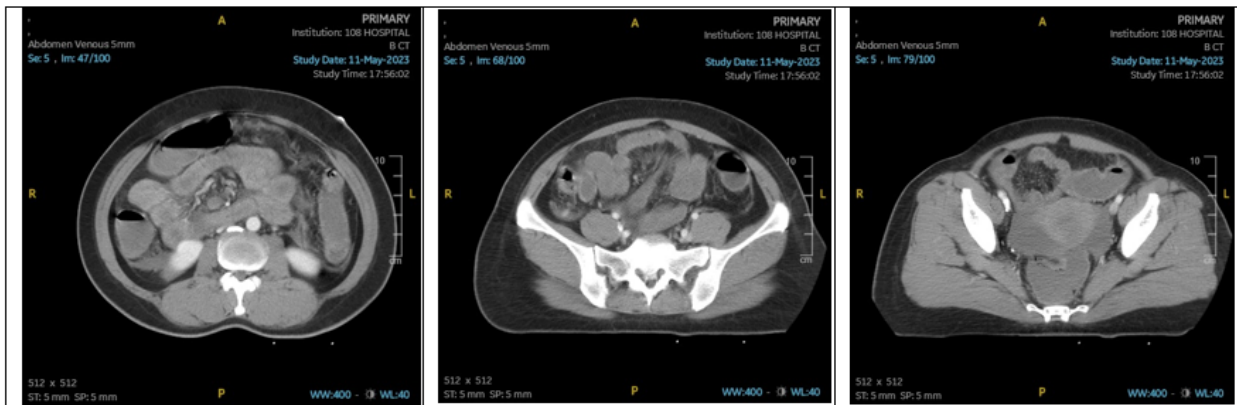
Abdominal computed tomography scan with contrast of patient shows moderate abdominal ascites, thickening of the bowel wall, and fluid-filled bowel loops in the small intestine with no pathological findings in the stomach, appendix, or colon, and no hepatosplenomegaly.
